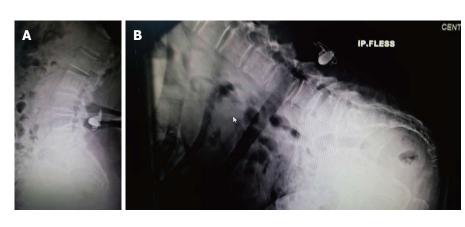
Dynamic X-ray. A: Patient treated for L3-L4 disc herniation (without instability at the dynamic X-rays) with an interspinous posterior device (IPD) implant. The Dynamic X-ray in extension showed a metameric instability at L3-L4 developed 1 year after an IPD implantation; B: Dynamic X-ray in flexion that showed an increase in L3-L4 slipping, developing a I° grade spondylolisthesis, due to the IPD implantation. The patient underwent revision surgery with removal of the IPD, decompressive laminectomy and L3-L4 stabilization with screws and rods.
